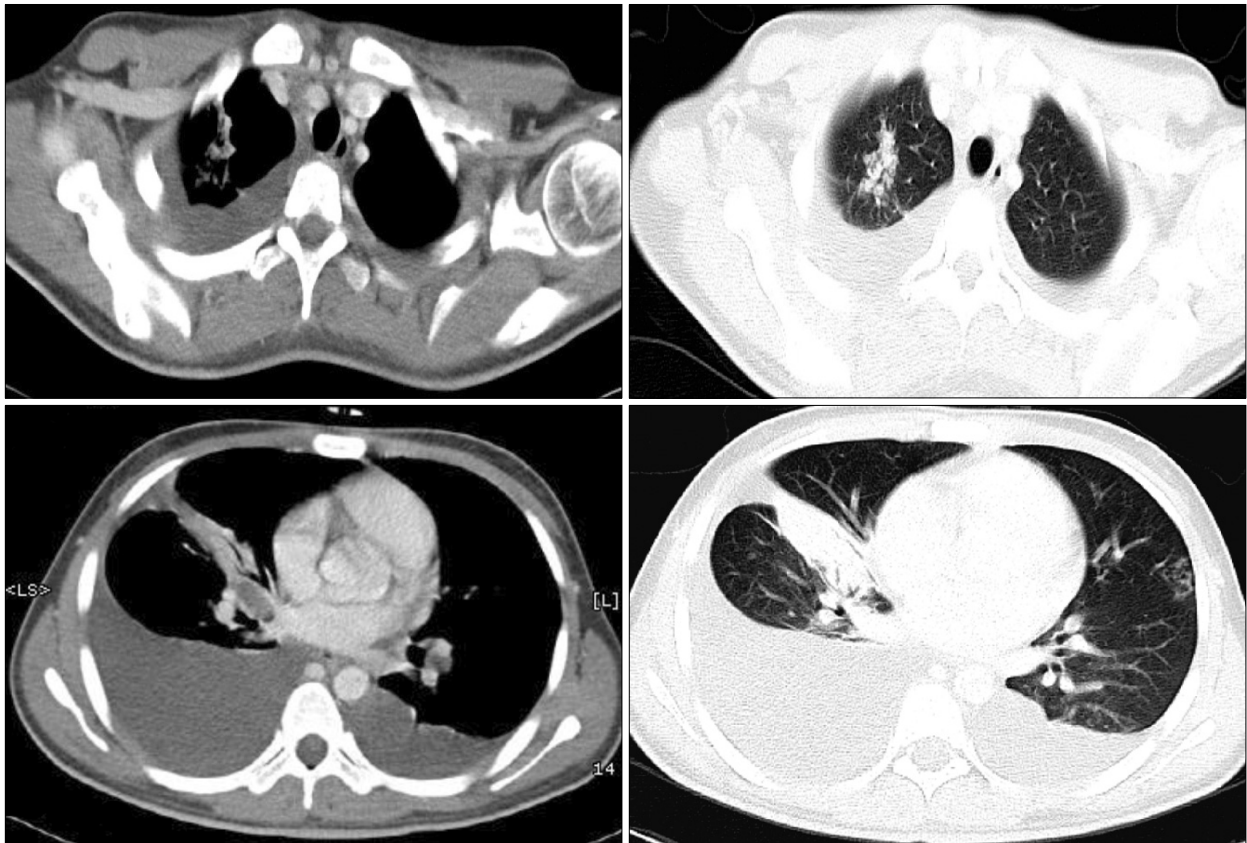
The Contrast enhanced CT scans of the chest showed low attenuation lesion in a bronchus lumen of right middle lobe and atelectasis. Both pleural effusion was noted. There was linear branching nodular opacity and ground glass opacity in both lung fields. No definite lymphadenopathy in mediastinum was noted.
